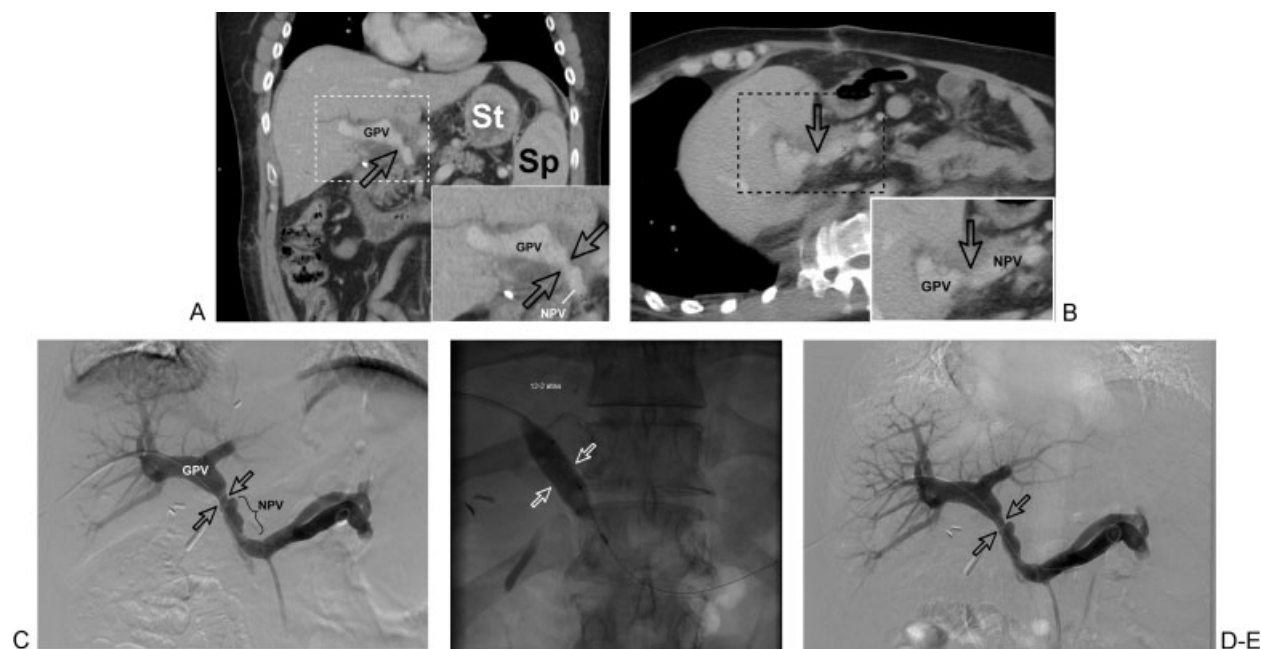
(A) Coronal reformat (with a magnified inset in bottom right corner) of a contrast-enhanced computed tomography (CT) of an adult liver transplant recipient with abnormal liver function tests. There is a stricture at the portal anastomosis (open arrows) between the native/recipient portal vein (NPV) and the graft/donor portal vein (GPV). St, stomach; sp, spleen. (B) Skewed coronal reformat (with a magnified inset in bottom right corner) of a contrast-enhanced CT of the same patient as (A). There is a redemonstration of the stricture at the portal anastomosis (open arrows) between the NPV and the GPV. (C) Digital subtraction portal venogram of the same patient demonstrating the portal anastomotic stricture (open arrows) between the NPV and the GPV. The pressure gradient across the anastomosis was 8 mm Hg. (D) Fluoroscopic spot image of an inflated 12-mm high-pressure balloon. The open arrows mark the site/level of the portal anastomosis. (E) Final digital subtraction portogram after venoplasty demonstrating no significant change in the portal anastomotic stricture (open arrows); however, the pressure gradient across the anastomosis improved from 8 mm Hg to 4 mm Hg. Due to the reduction of the gradient to a satisfactory level, no further interventions were performed.
